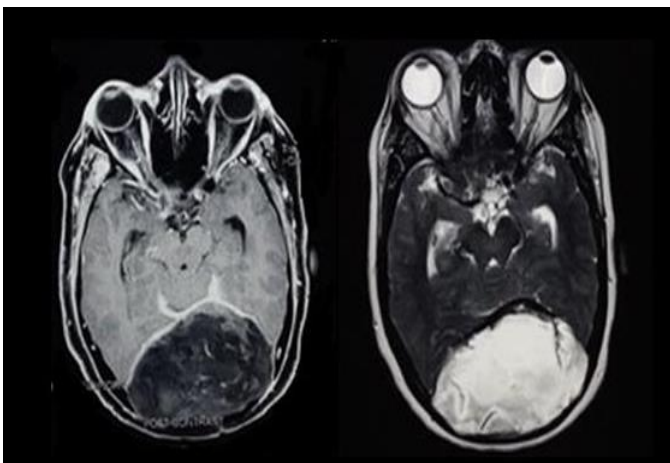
MRI brain T1W with contrast showing non-enhancing circumscribed lesion in the occipital bone along with T2 hyperintensity of the lesion in the second image.
